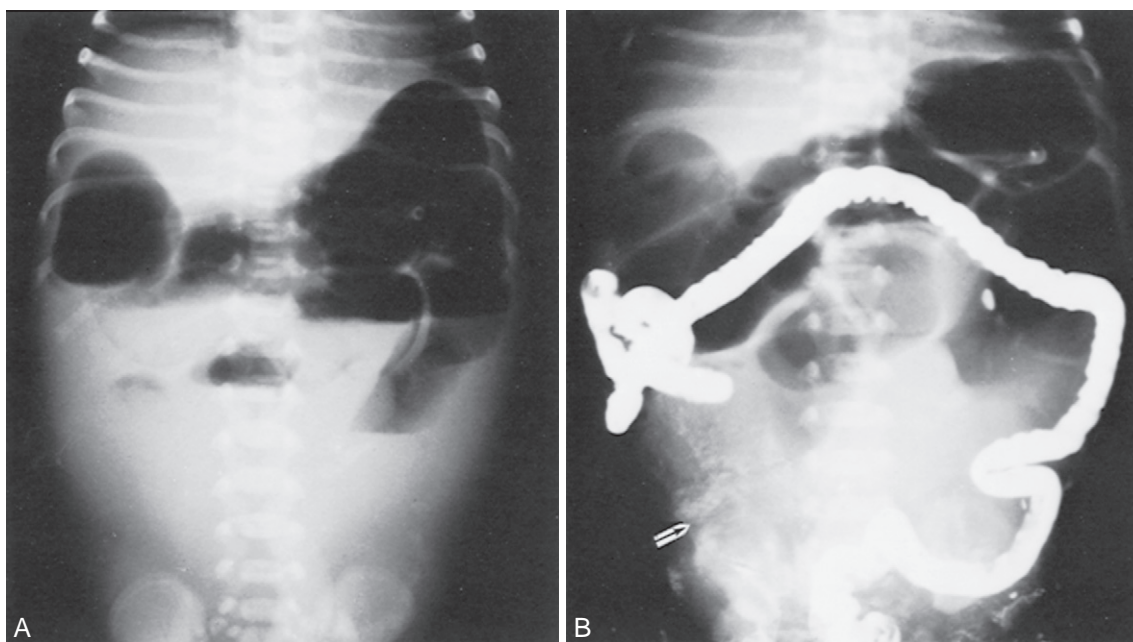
Meconium peritonitis. A, Erect radiograph of the abdomen demonstrates greater than thumb-sized loops of intestine with multiple air-fluid levels. B, Barium enema demonstrates a microcolon with incomplete rotation (cecum in right upper quadrant) and calcification in the right lower quadrant (arrow) indicative of meconium peritonitis (From Grosfeld JL: Alimentary tract obstruction in the newborn. *Curr Probl Pediatr* 1975;5:3).
